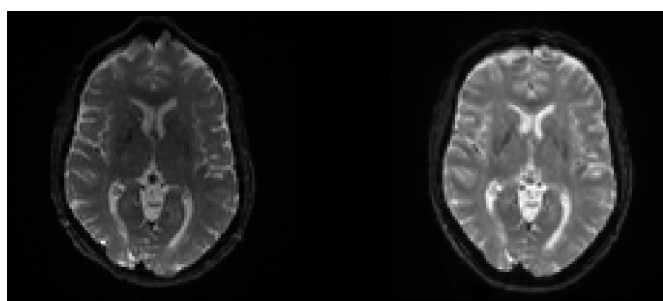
Susceptibility artifacts can be seen in the anterior parts of the brain in the DWI to the left. To the right, a b0-image can be observed of the same individual and slice after preprocessing with FSL.
